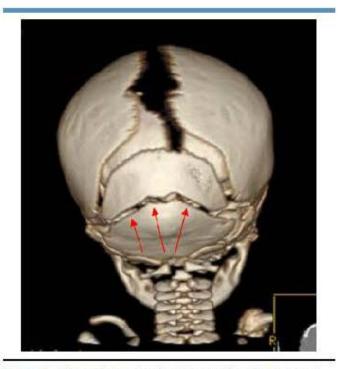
Three-dimensional reconstruction of computed tomography of the head, 0.625-mm slices. Arrows show persistent mendosal suture.
